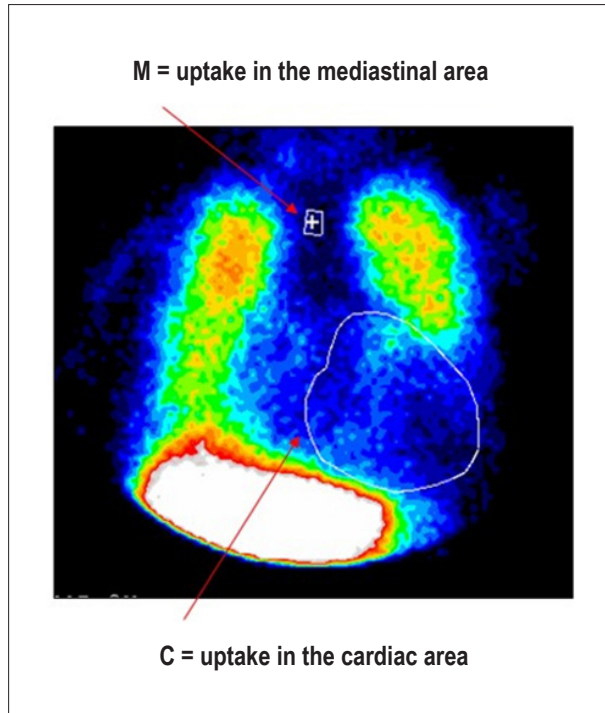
Cardiac scintigraphy with MIBG-¹²³I. Colored late imaging of the anterior thorax with the regions of interest (ROI) drawn in the mediastinal (M) and cardiac (C) areas, to calculate the heart to mediastinum ratio (HMR) of MIBG-¹²³I uptake. This index is the measure of the ratio between the statistical count of the rate of average radiation per pixel in the ROI, drawn in the heart and mediastinum.
